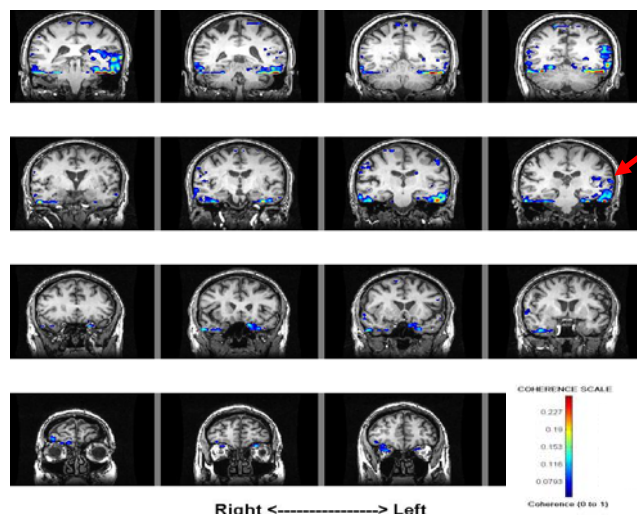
MEG Coherence analysis of spontaneous activity while patient perceived his tinnitus. MRI shows localization of activated cortex in the Left Auditory Cortex. Red indicates cortical areas that are highly coherent with all other brain regions. This patient had unilateral tinnitus in the right ear.
